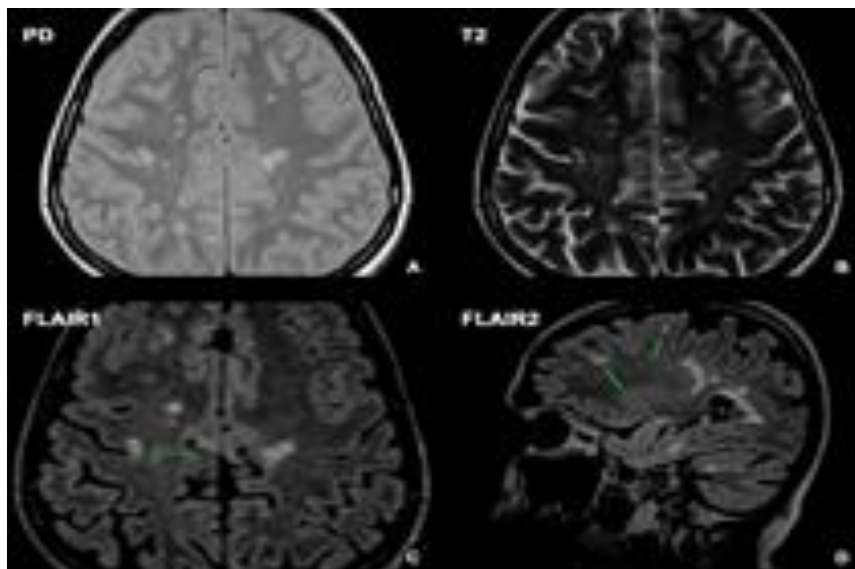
Foci of an irregular oval shape with clear contours, hyperintense MR signal on T2/FLAIR, and hypointense on T1 are visualized bilaterally juxtacortically, periventricularly in the white matter of the frontoparietal and temporal lobes, perpendicularly to the corpus callosum (“Dawson's fingers”), in the brainstem and cerebellar peduncles. Their maximum dimensions in the right parietal lobe are up to 10x9mm, and in the left parietal lobe – 14x8mm. Some of the periventricular foci of the right and left cerebral hemispheres have signs of diffusion restriction on the DWI/ADC map. The U-shaped, 9x6mm dimensions focus, marked by an arrow, is located juxtacortically on the right in the frontoparietal region and could be the seizure onset zone
